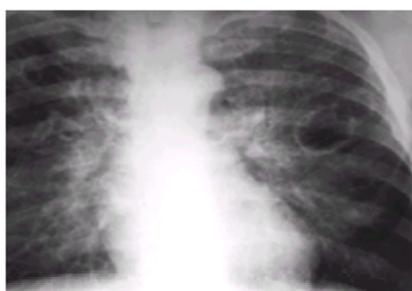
The classic radiographic appearance of *Pneumocystis carinii* infection in an immunocompromised patient is that of hazy perihilar infiltrates, although the range is broad, from normal-appearing lungs to lobar consolidation. Parenchymal cystic and thin-walled cavitory changes have been associated with *Pneumocystis* infections, typically in the upper lobes. Two such cysts are evident in the left upper lobe of this AIDS patient with *P. carinii* infection.
